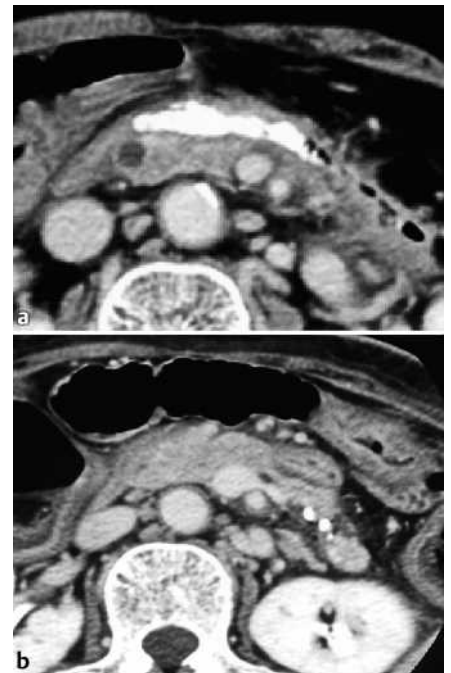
Post-treatment computed tomography scans. a Three weeks after treatment, a pool of Lipiodol could be seen filling the entire cyst cavity. b Three months after treatment, the fistula had shrunk and disappeared.
